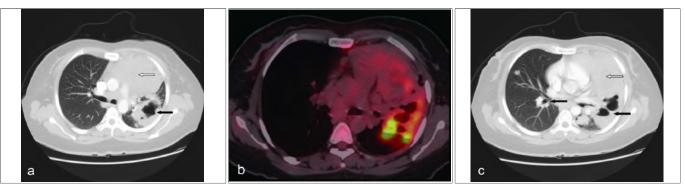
(a,b,c): CT scan of chest showing a large anterior mediastinal mass (1A & 1C, white arrows) and multiple cavitary lesions in both the lungs (1A, 1C, black arrows). FDG-PET/CT scan showing FDG avid cavitary consolidation in the left upper lobe (Figure 1B), mainly in the lingual area with SUVmax 4.1.
